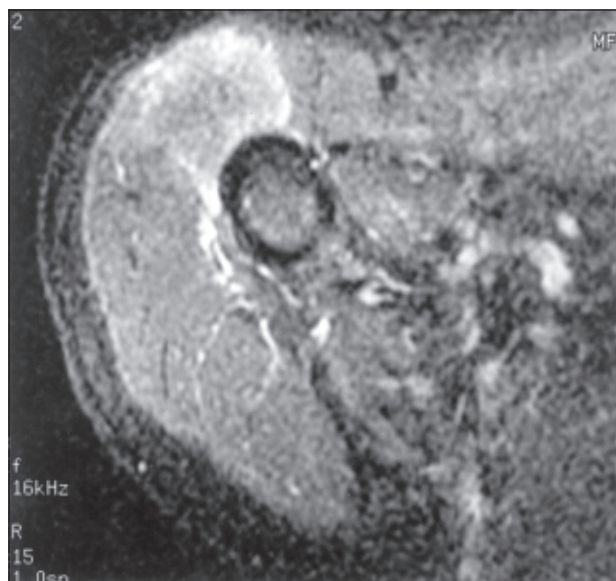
Axial non-contrast T1-weighted image through the right upper arm (TR 600, TE 14) demonstrates a mass within the anterior portion of the deltoid measuring 2.8 × 2.3 cm in size (arrow).
